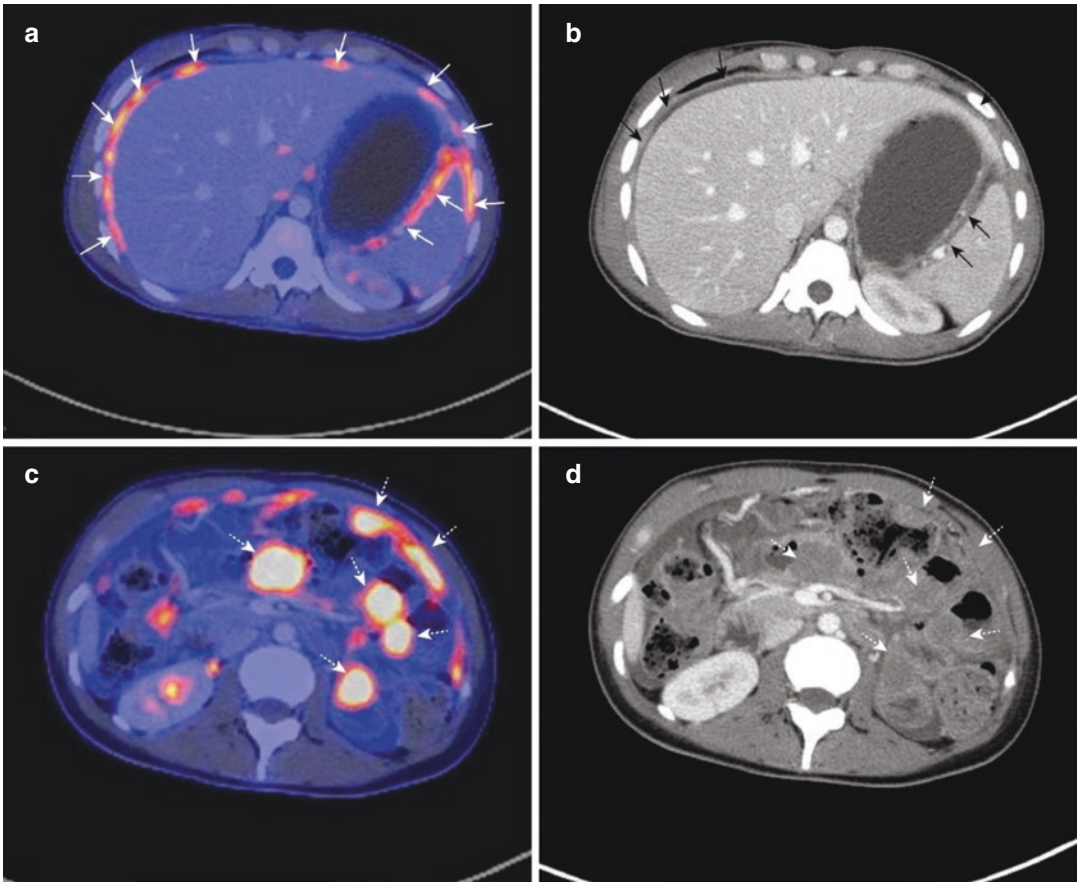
(a–d) The ^{18}F -FDG-PET/CT images of a 34-year-old patient with peritoneal malignant mesothelioma depict two different patterns of peritoneal tumor dissemination: (a, b) hypermetabolic laminar diffuse thickening of the complete peritoneum, (c, d) hypermetabolic focal macronodular interenteric masses. On corresponding
